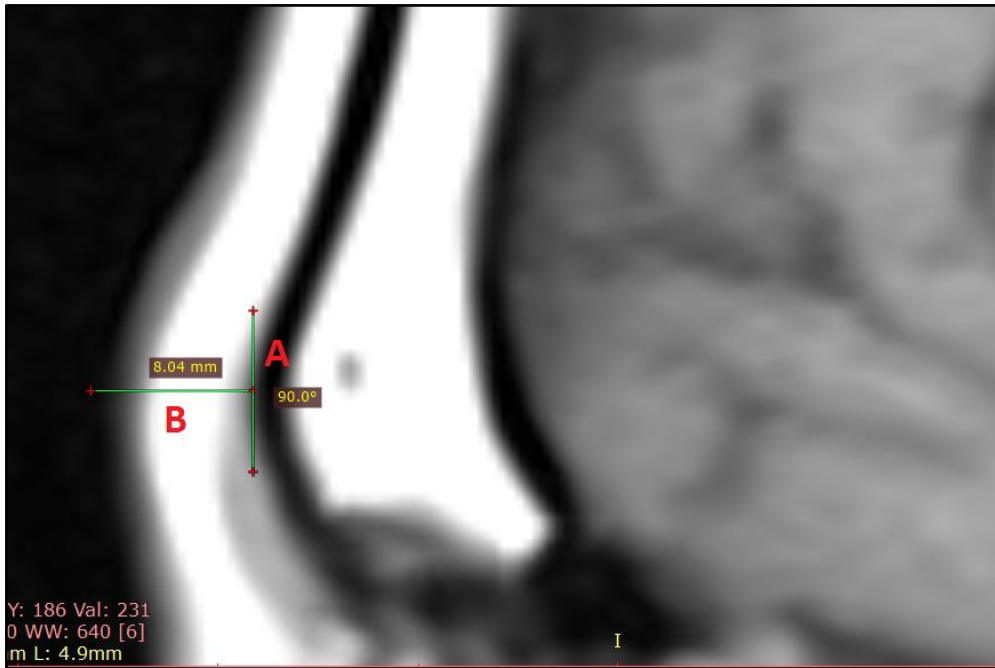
Establishment of FSTT measurements on MRI
